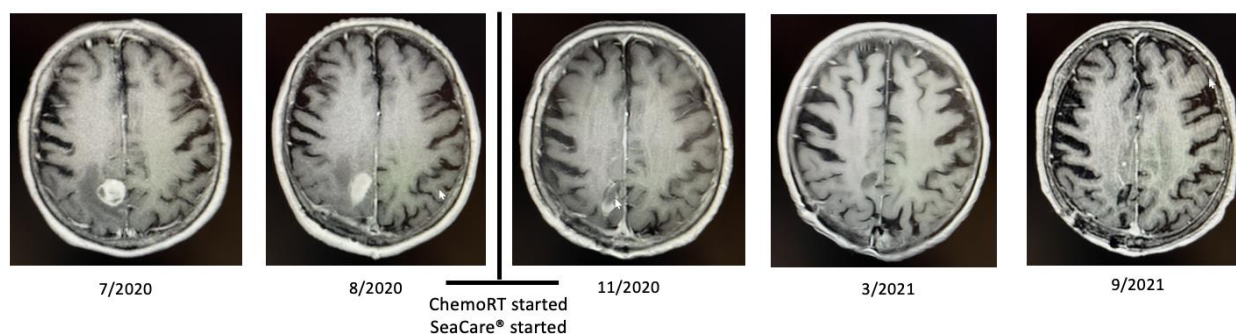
Serial radiographic response of Patient 1. Gadolinium-enhanced MRI shows a significant decrease in tumor size after a 6-week course of concurrent chemoradiation and the initiation of marine nutraceutical products. Even in the absence of adjuvant temozolomide, she achieved a durable response on maintenance marine nutraceuticals alone.
